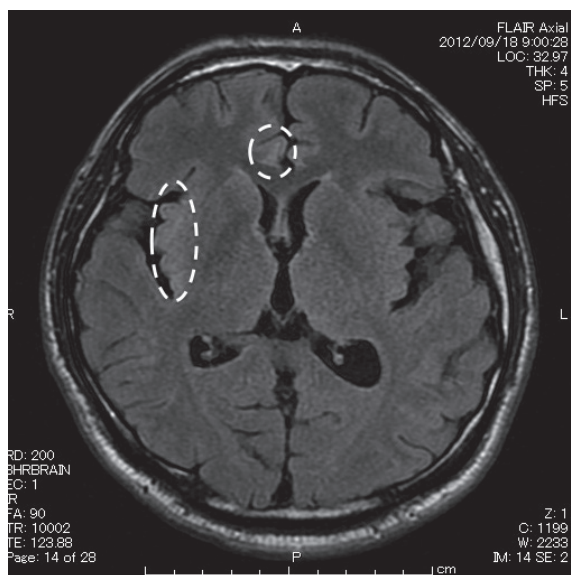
Brain image of MRI: There were isolated lesions showing high signal intensity on FLAIR 2 (Fluid Attenuated Inversion Recovery) image in right frontal lobe and right insular cortex (circle); this is a manifestation of limbic encephalitis.
